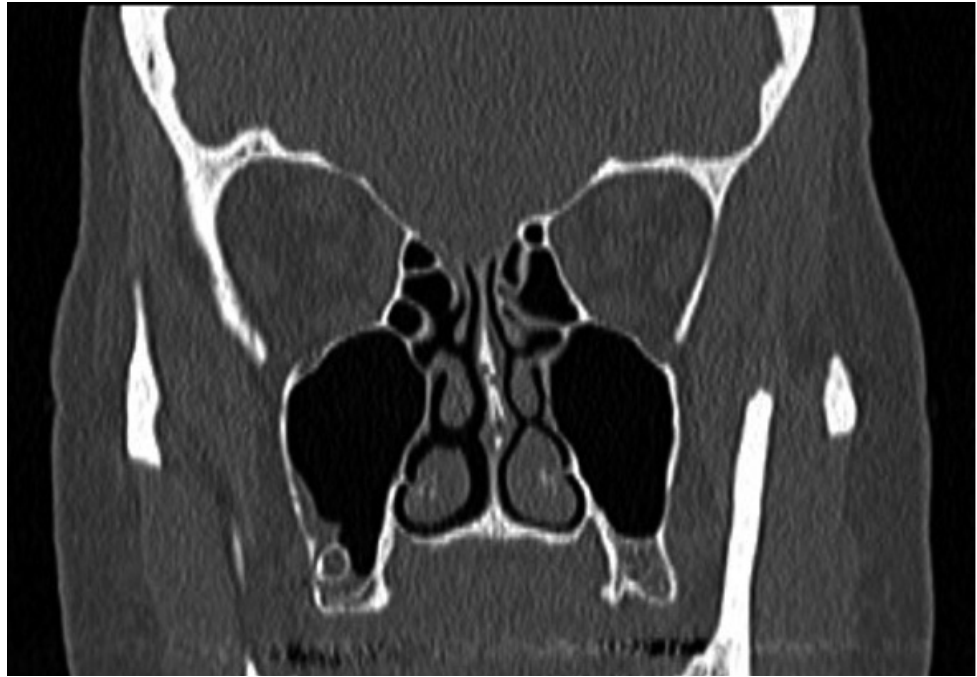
Computed tomography scan of the ethmoid and maxillary sinuses in coronal view.
